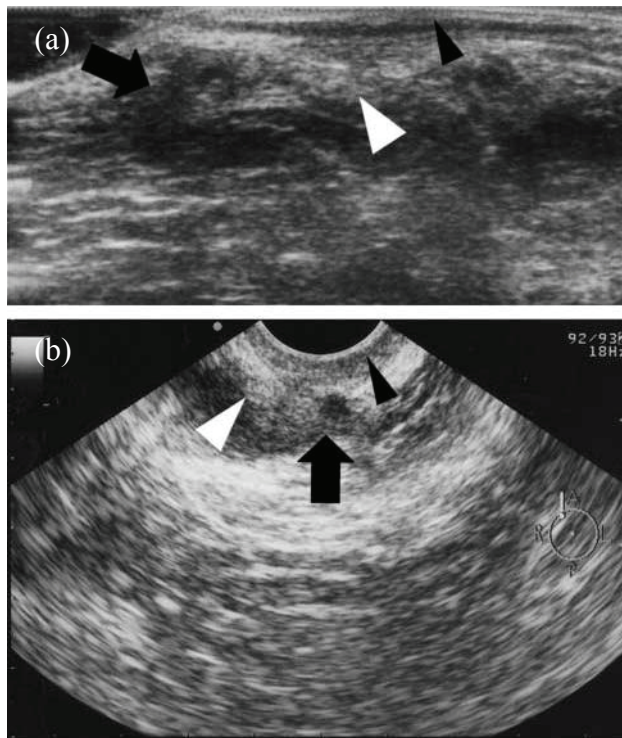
A 30-year-old woman with a mass in the right anterior perineal region adjacent to an episiotomy scar. Linear (a) and radial (b) ultrasound showed a heterogeneous mass containing cystic anechoic areas (black arrow) in the right anterior perianal region; the mass seemed to involve the external anal sphincter (white arrowhead) and not to involve the internal anal sphincter (black arrowhead). (Toyonaga, 2006)
